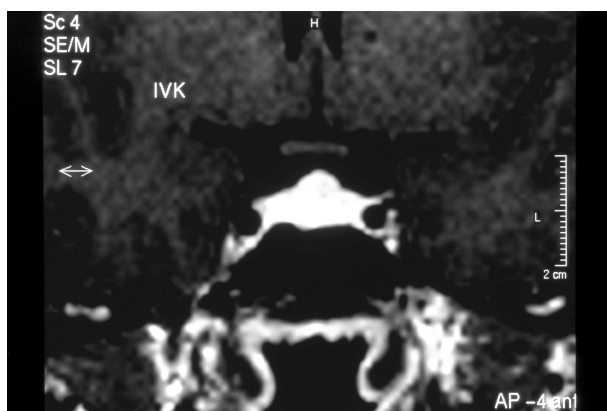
MRI image of the pituitary gland in euthyroid state. The gland volume is remarkably decreased in fig. 2 compared with fig. 1.
